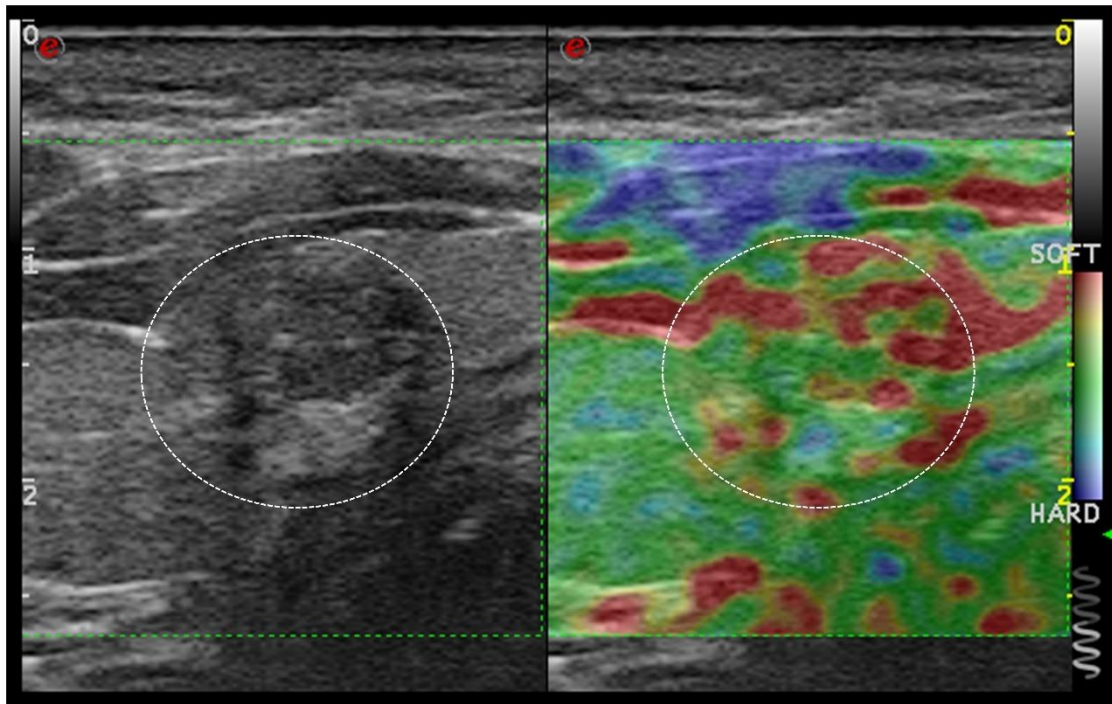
9 Representation of a nodule in grey scale ultrasound (white dotted oval area) and the corresponding SE colour map of the nodule area to indicate stiffness.
